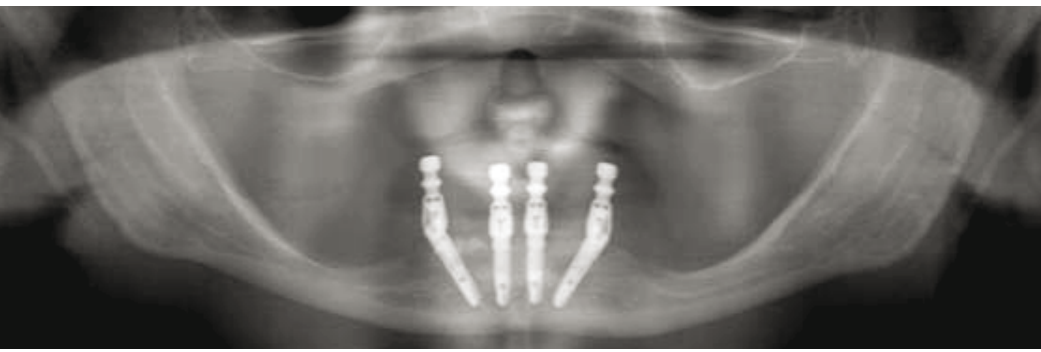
Orthopantomogram after four months of implant healing
